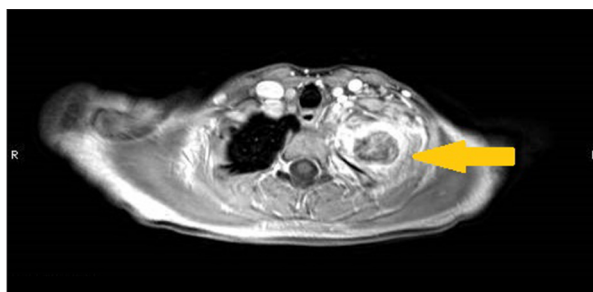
MRI of the chest showing a heterogeneously enhancing lesion with areas of sclerosis involving and expanding the first left rib and associated with a large enhancing soft tissue component (arrow).
